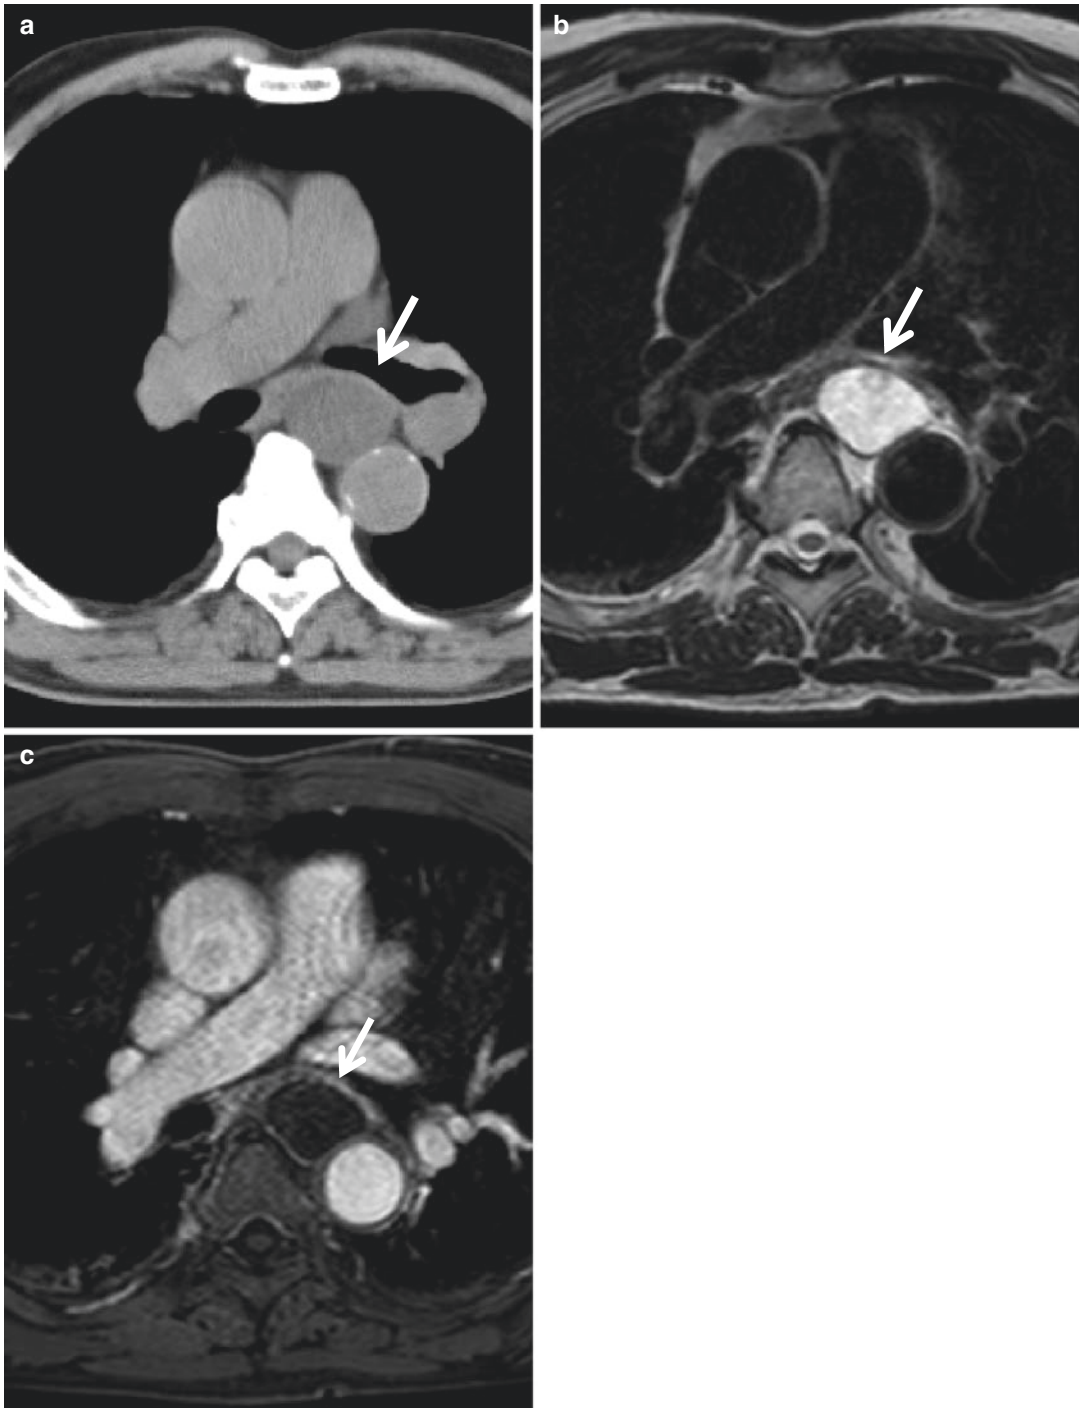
Bronchogenic cyst. (a) Non-contrast-enhanced CT, (b) T2-weighted, and (c) contrast-enhanced MR images. There is a well-demarcated mass lesion in the subcarinal region (*arrows*). The mass shows soft tissue
